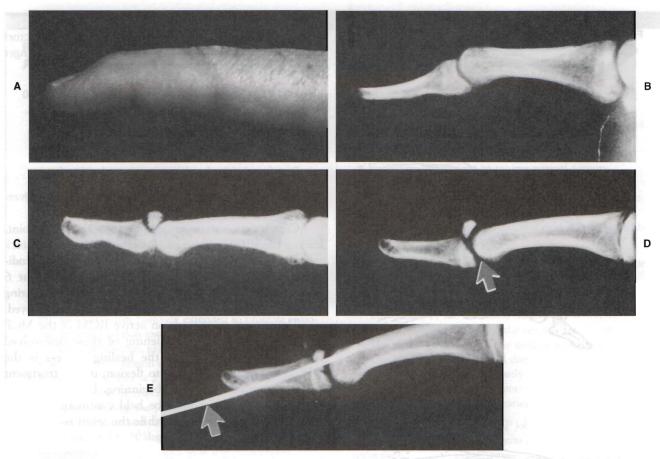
A*, Mild mallet finger deformity (extensor lag at the DIP joint with an inability to extend the DIP joint) seen as a flexed DIP joint. It is important to treat this acute injury before further tearing of the extensor tendon and stretching of new scar tissue lead to greater deformity. *B*, No bony injury is seen on the radiograph. After 6 weeks in a splint, the finger was nearly normal. *C*, Note that the palmar fragment is concentrically reduced with the middle phalanx. In spite of a large dorsal fragment, which makes up more than one third of the articular surface, continuous splinting for 8 weeks resulted in pain-free function with only a trivial decrease in ROM. *D*, Mallet finger with a subluxated palmar fragment may need surgical reduction and internal fixation. *Arrow* points to the loss of concentricity of the joint surfaces. *E*, Intraoperative radiograph shows reduction and pinning (*arrow*) through a dorsal-ulnar approach without sectioning of the extensor tendon. Note the restored concentricity of the joint surface. (*A*–*E*, From Vetter WL: How I manage mallet finger. Physician Sports Med 17[3]:17–24, 1989.)
